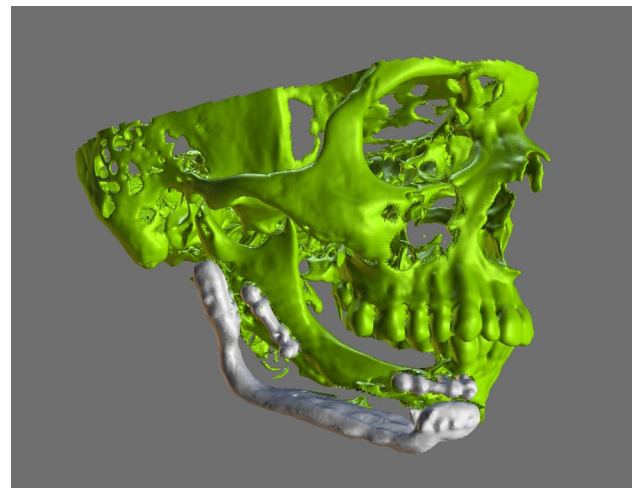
Post-operative CT scans showing good stability of PSI with no hardware failure
